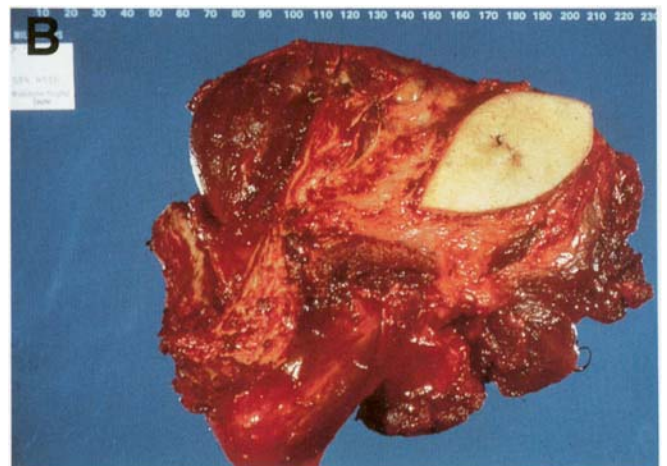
CT scan of an extremely large scapular tumor with extension to the chest wall and involvement of all of the adjacent muscles.
